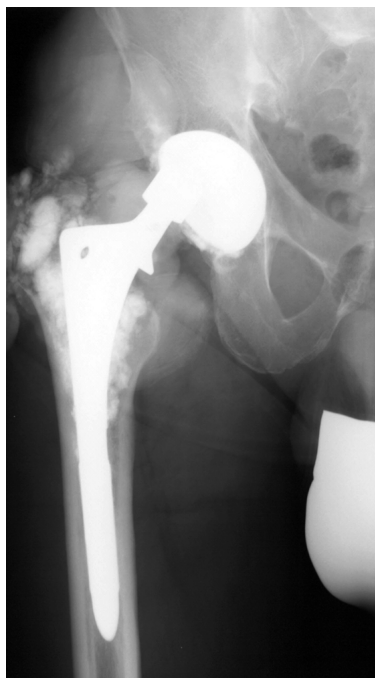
Deterioration of the metal head on radiographic control 3 years after revision surgery.
